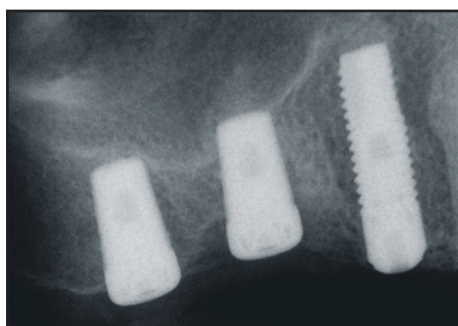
Immediate postoperative radiograph once the 5-mm x 7-mm implants were placed with osteotome-mediated sinus floor infraction.
